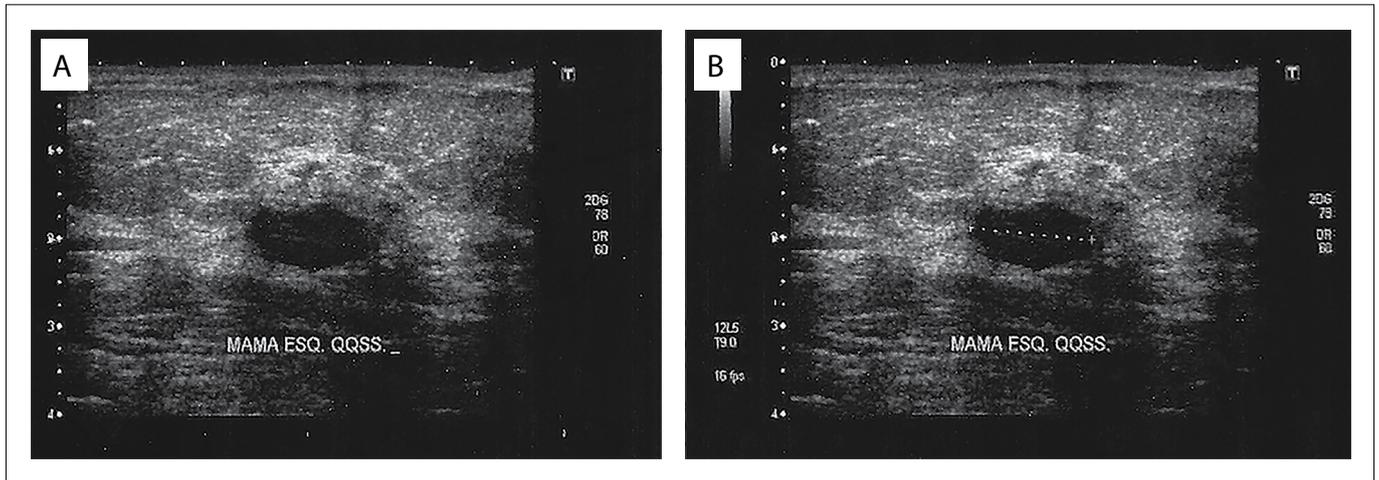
Sonographic findings in breast leiomyoma, demonstrating a hypoechoic oval mass that was predominantly circumscribed but sometimes showed microlobulated margins, and which was parallel to the breast skin. It was classified via ultrasonography in Breast Imaging-Reporting and Data System (BI-RADS) category 4.
